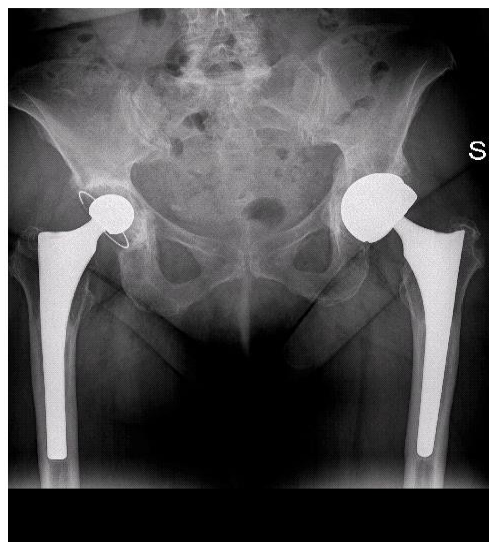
Pre-operative X-rays.
